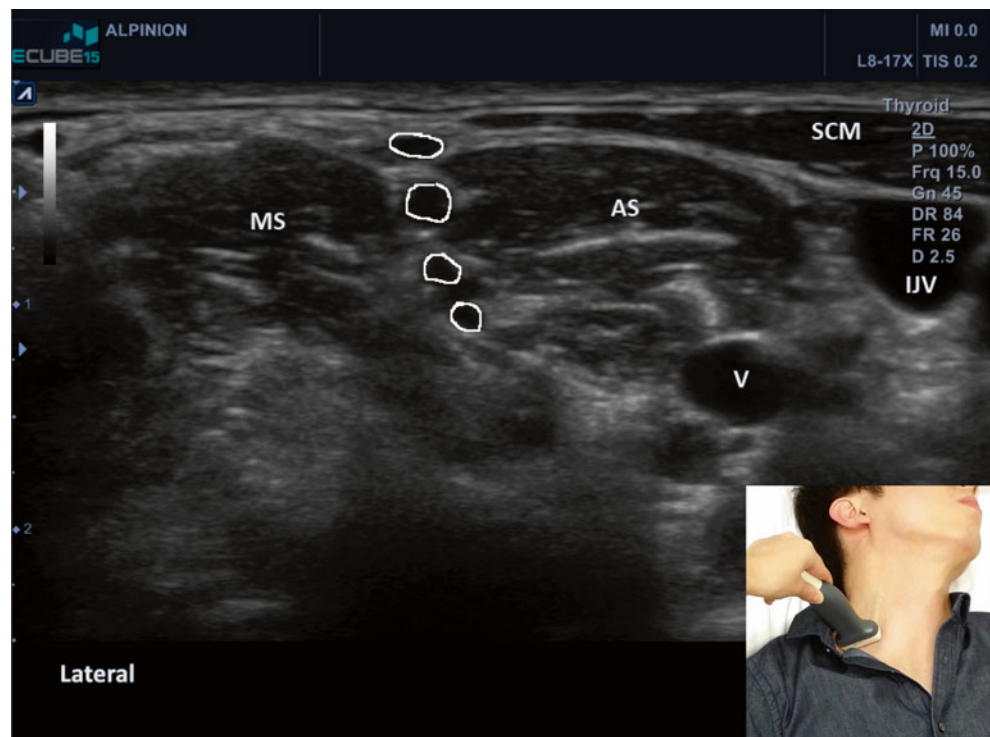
Ultrasound image of the thoracic outlet. Horizontal ultrasound probe with the head turned to the contralateral side. *SCM* sternocleidomastoid muscle, *AS* anterior scalene muscle, *MS* middle scalene muscle, *circles* brachial plexus. *IJV* internal jugular vein, *V* vein (Image courtesy of Virtaj Singh, MD)
